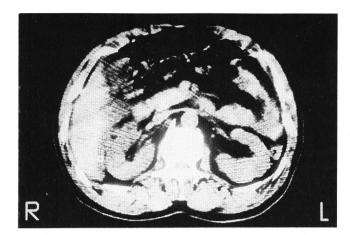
CT: accumulation of peritoneal fluid and distended gut
